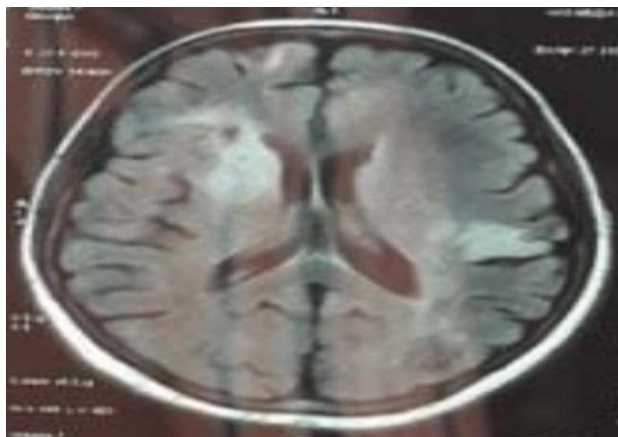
MRI brain T2 sequence showing subacute infarcts in bilateral cerebral hemispheres.
